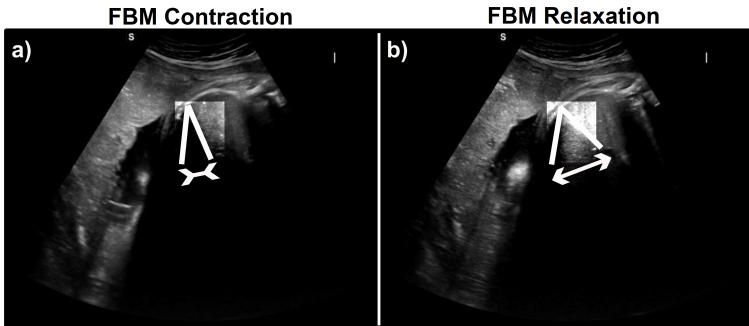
Contraction and relaxation of the diaphragm in the sonographic measurements
